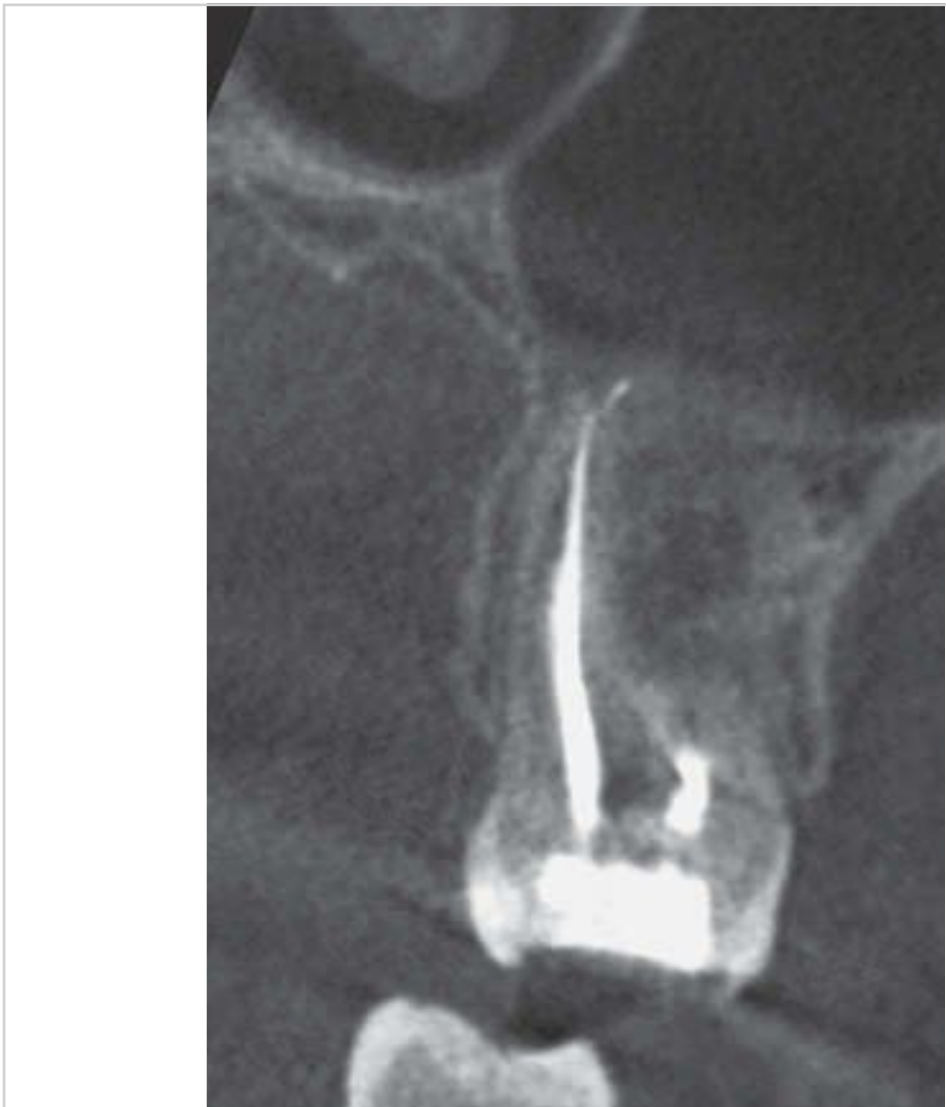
CBCT coronal view of tooth 26.
